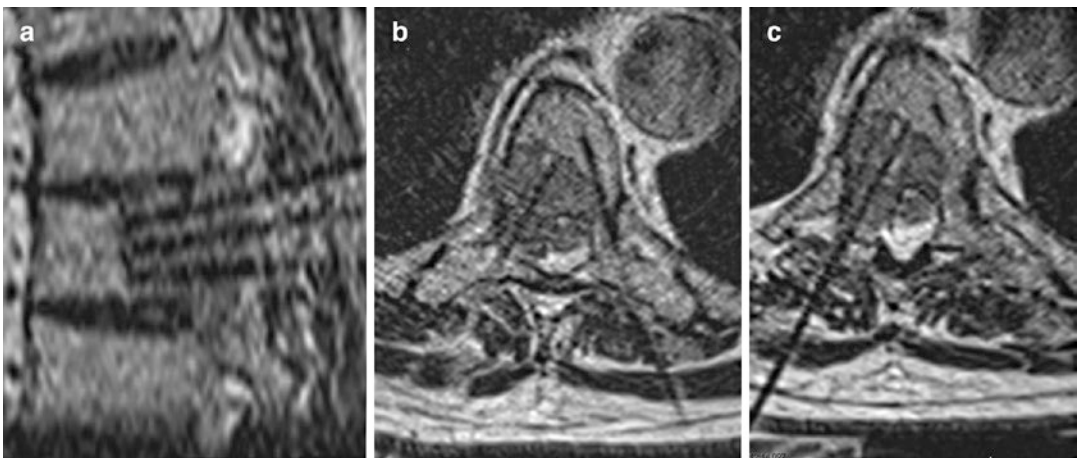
Once the patient is transferred back to the iMRI, a trajectory localization scan is obtained. This MRI T2 sequence is utilized to confirm the exact place for each access cannula in the (a) sagittal and (b,c) axial planes
